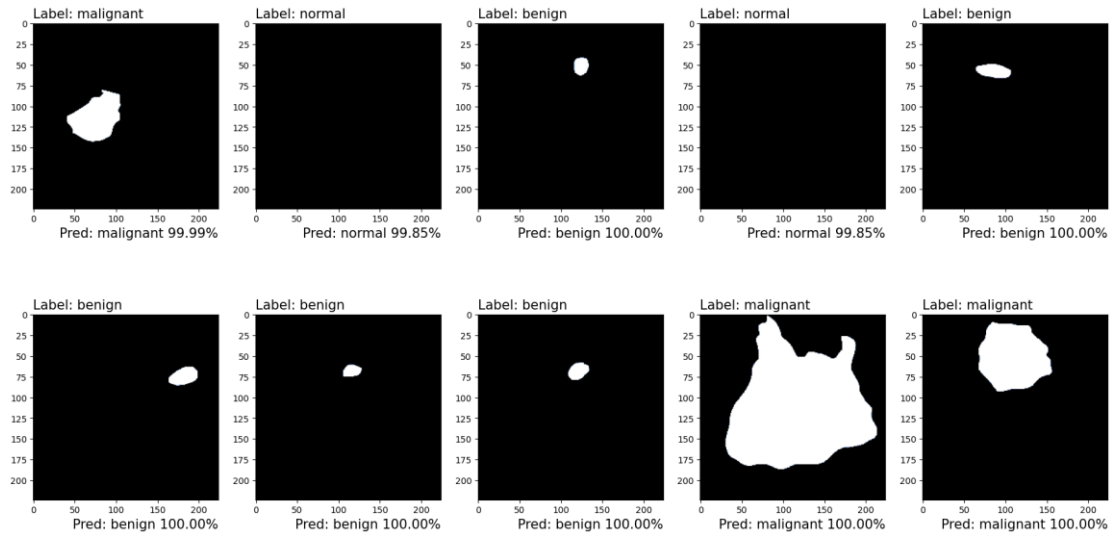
Segmented Outcome of Ultrasound Image Using Fuzzy Fusion-Based Segmentation
